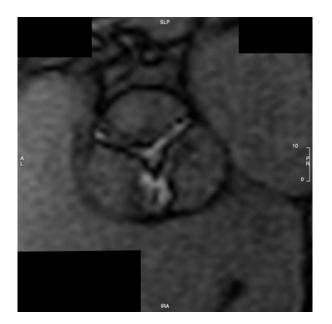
CMR planimetry of aortic valve. Cardiac MRI planimetry of a severely stenotic aortic valve.
